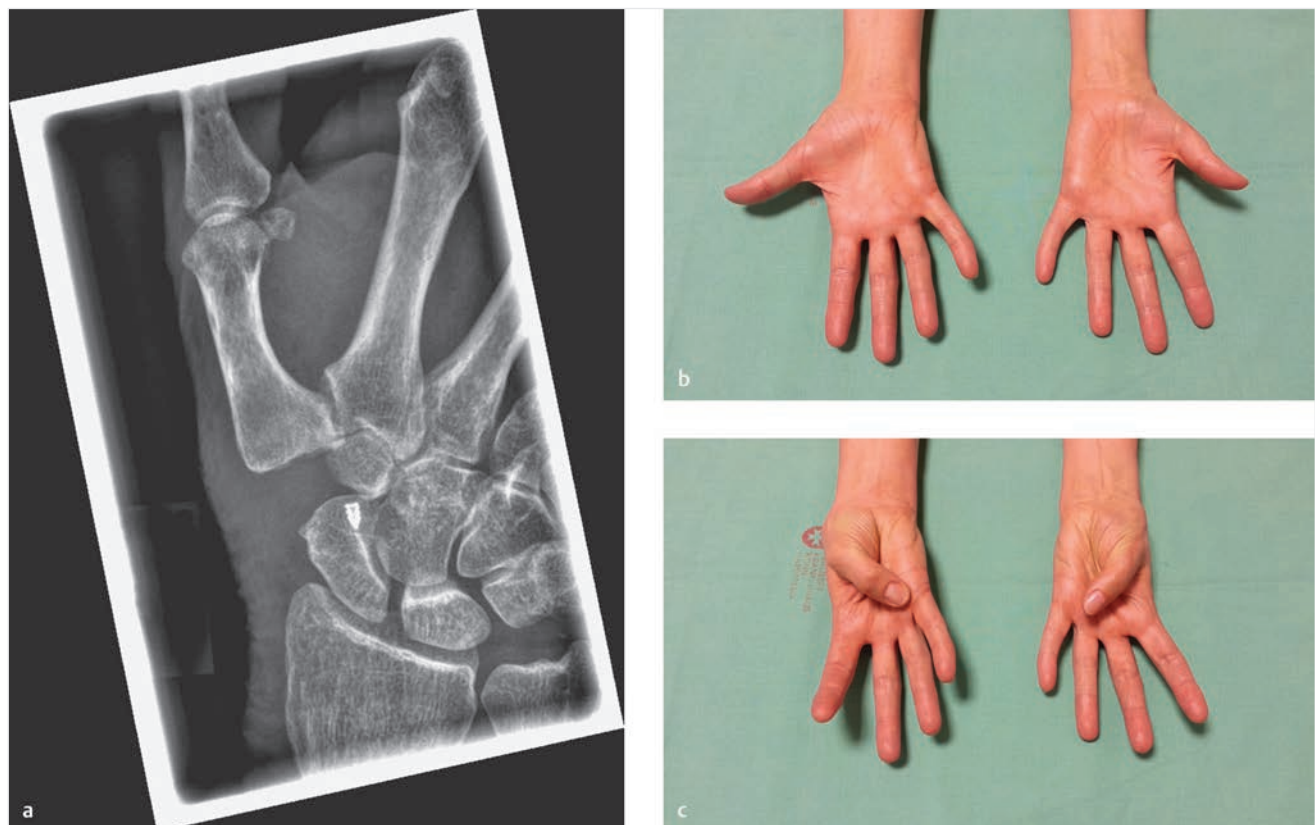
(a) X-ray after surgery shows almost normal trapezial height. (b,c) Functional results 1 year after implantation of a rib cartilage.
